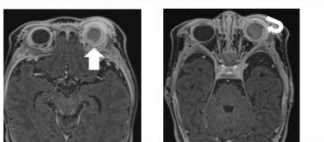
Axial T1-weighted post-contrast MRI images of a 40-day-old girl with left eye retinoblastoma. There is mural defect in the posterior aspect (arrow) and lateral aspect (curved arrow) of the choroid layer of left globe, suggestive of invasion. Noted there is also optic orbital cellulitis in the left globe, which is another imaging feature indication of high grade retinoblastoma.
